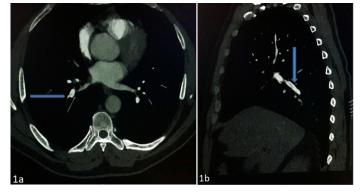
Pulmonary CT angiographic examination showing hypodense linear thrombotic material causing filling-defects at the subsegmental level of the lobar branch of both main pulmonary arteries consistent with embolism (arrow)
